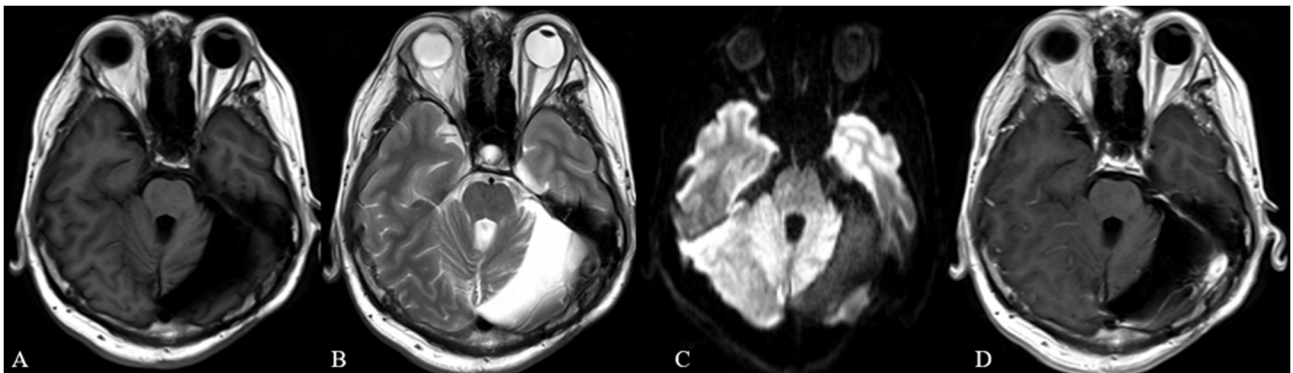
Head magnetic resonance images at 1 year after surgery. The images, including (A) T1WI, (B) T2WI, (C) diffusion-WI and (D) contrast-enhanced T1WI indicated no tumor residue or recurrence. WI, weighted imaging.
